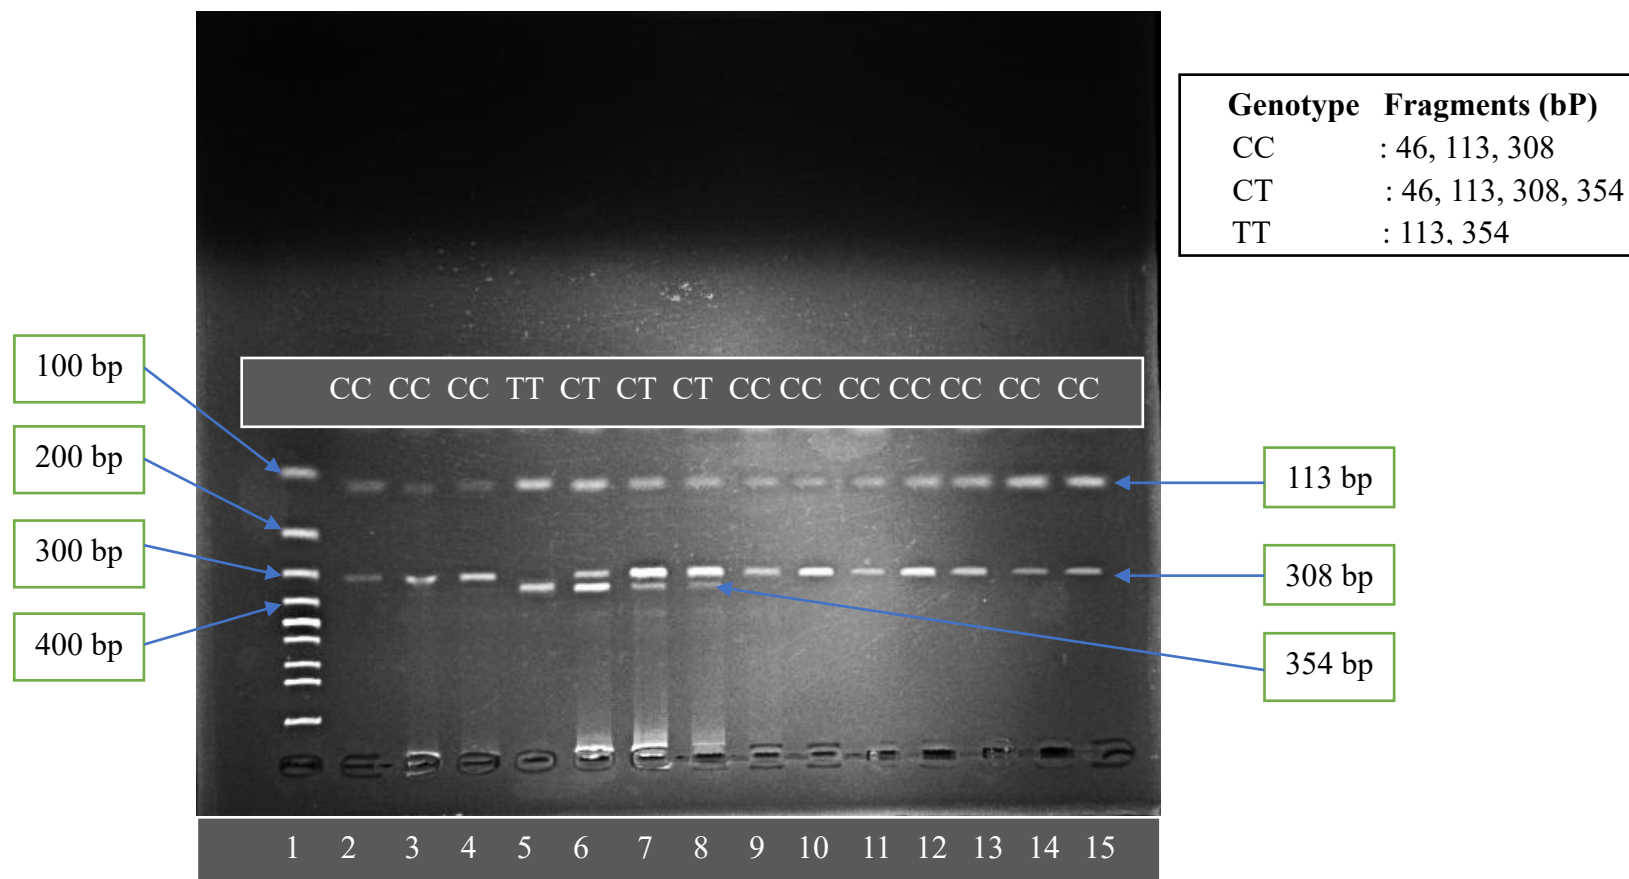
Restriction Endonuclease (BseRI) digestion fragments of rs11572080 allele after 2.0 % agarose gel. Lane-1: 100 bp DNA ladder. Lanes-2, 3, 4, 9, 10, 11, 12, 13, 14, 15: CC; Lanes- 6, 7, 8: CT; Lane- 5: TT.
